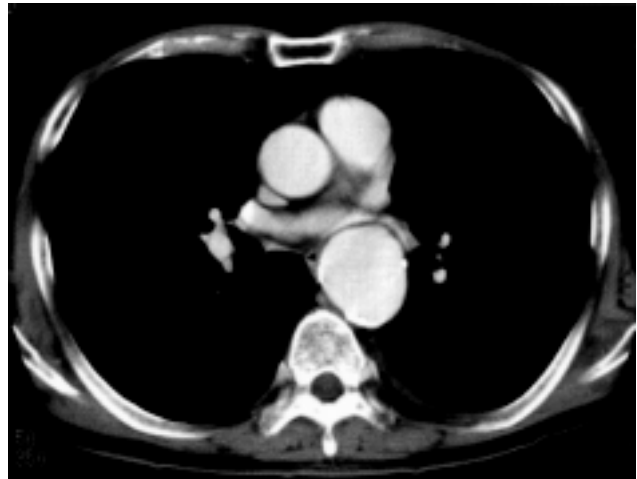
The enhanced computed tomography shows an aneurysm of the descending aorta. The maximal diameter of the aortic aneurysm was 55 mm.
